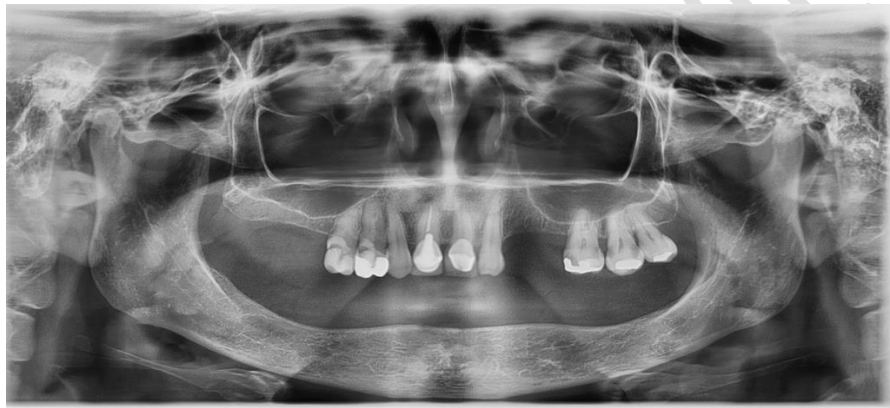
Panoramic radiograph with presence of remaining dental organs in the maxilla and presence of residual ridge pathology in the mandible. The presence of bone lesions is not appreciated.
